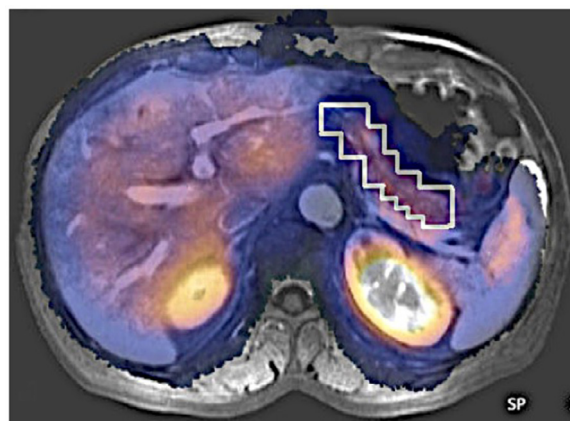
Axial sections of SPECT/MRI with $^{99\text{m}}\text{Tc}$ -HYNIC IL2 showing increased pancreatic uptake in a patient with insulinitis.
